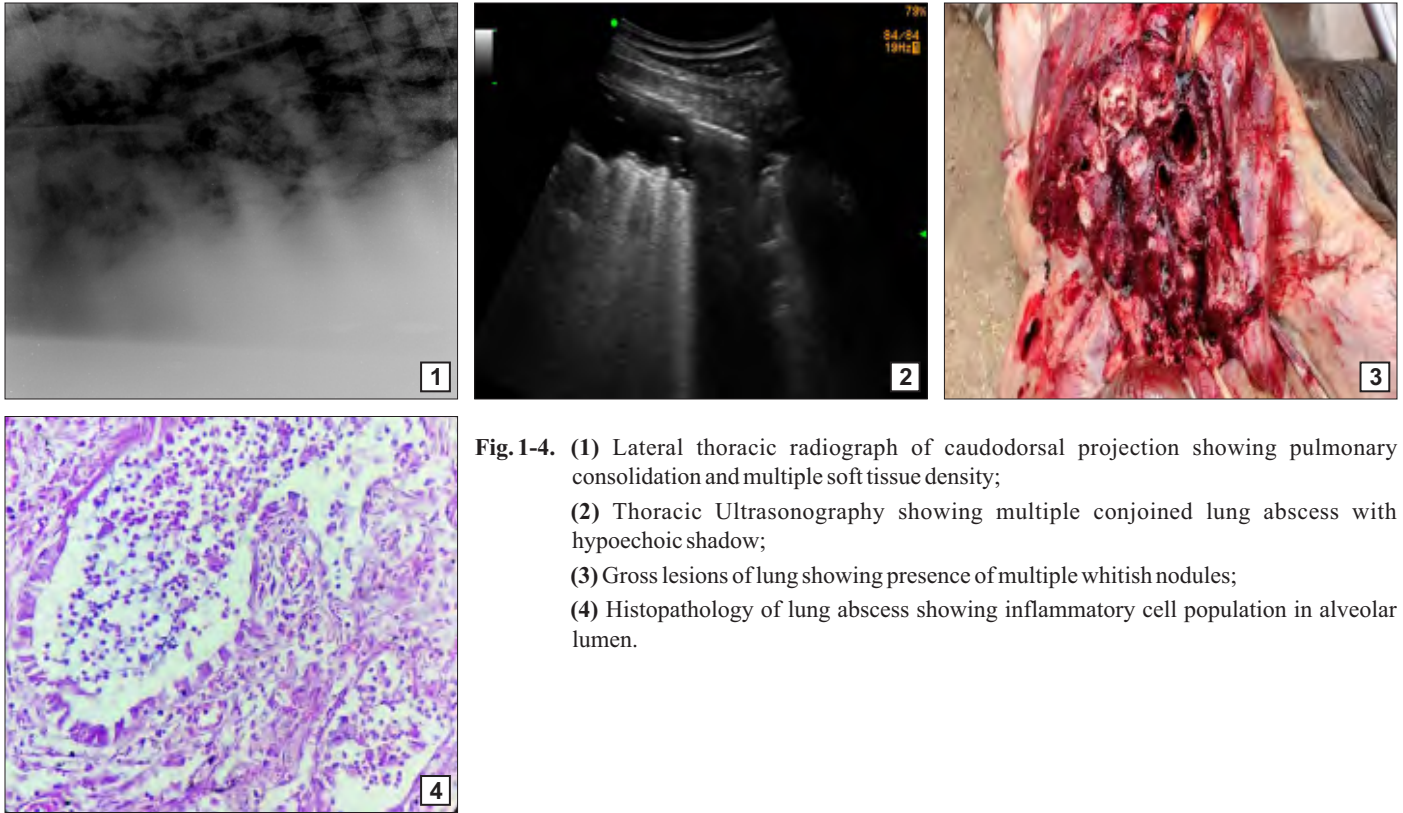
(1) Lateral thoracic radiograph of caudodorsal projection showing pulmonary consolidation and multiple soft tissue density;
